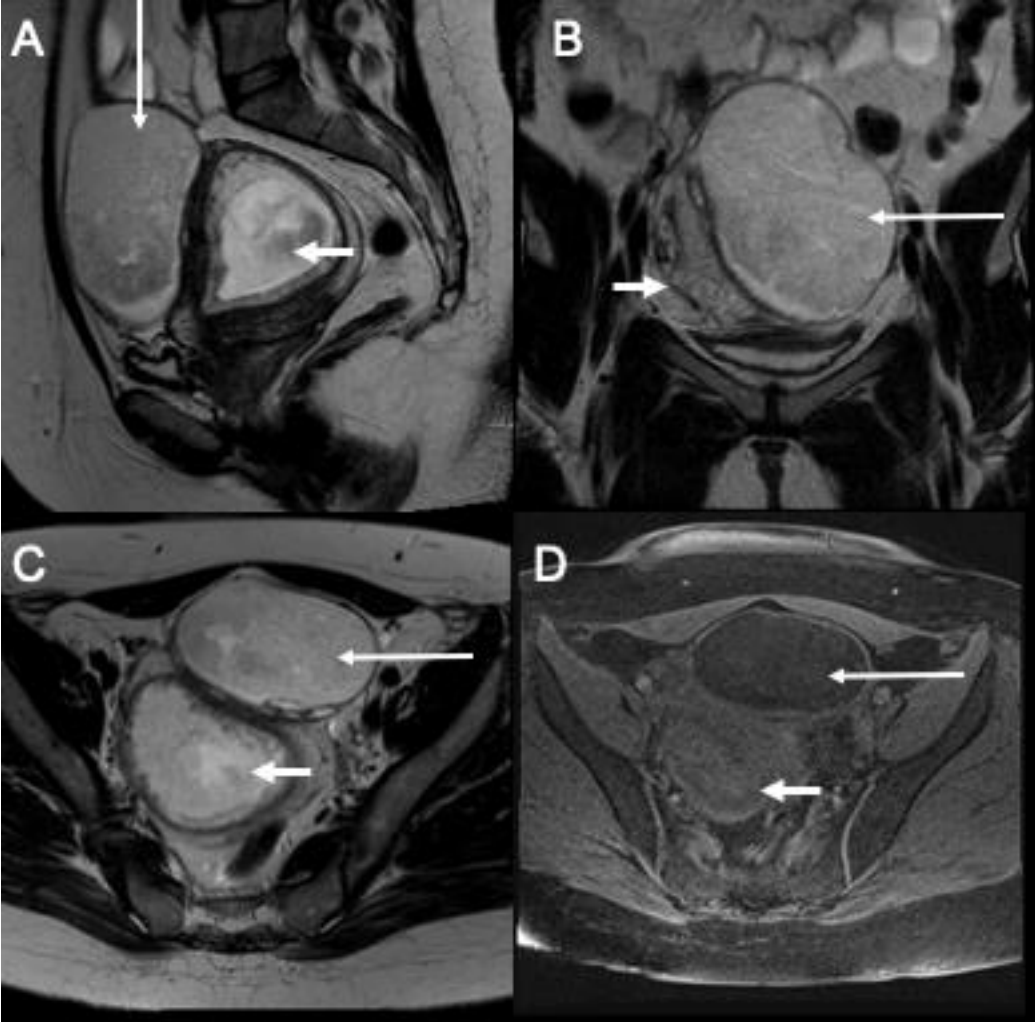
MCT in a pregnant woman evaluated with MRI. Thin-walled cystic lesion with predominantly adipose content (long arrow) located in front of the gravid uterus (short arrow). The fat is the slightly heterogeneous signal on T2-weighted images (A, B, C) and shows a signal loss on T1 fat-suppression (D).
